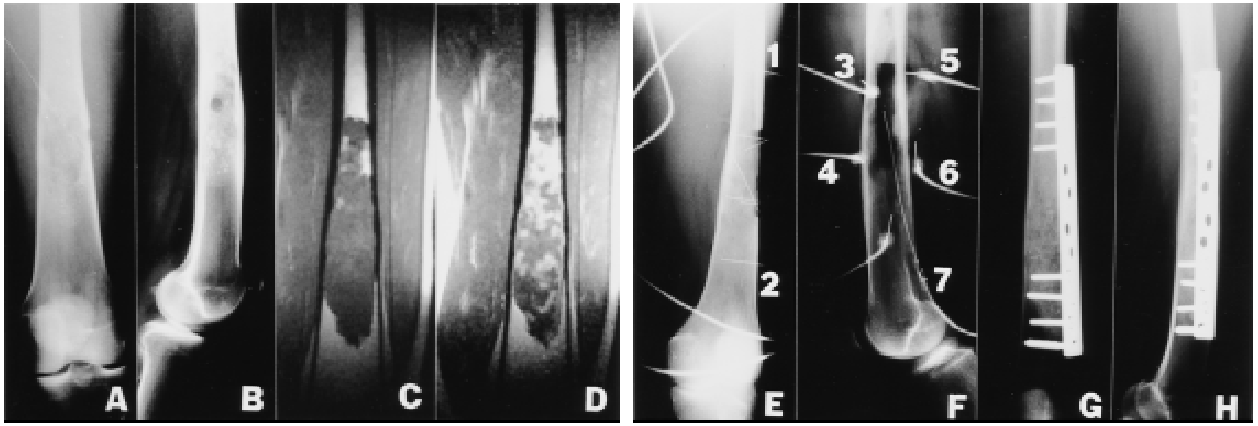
Postbiopsy routine radiographs of a 29-yr.-old female with chondrosarcoma, grade 1 of diaphysis of the femur (A,B). Magnetic resonance imaging, T1 (C) and T2 (D) weighed showing erosion of cortex and an inhomogeneous signal intensity consistent with enchondroma or low-grade chondrosarcoma. Intraoperative radiographs showing localization of the temperature couples. Number 7 is situated in the curetted lesion. Numbers correspond with those in Figure 3B (E,F). After curettage and cryosurgery, the cyst is filled with homologous bonegraft (G,H).
